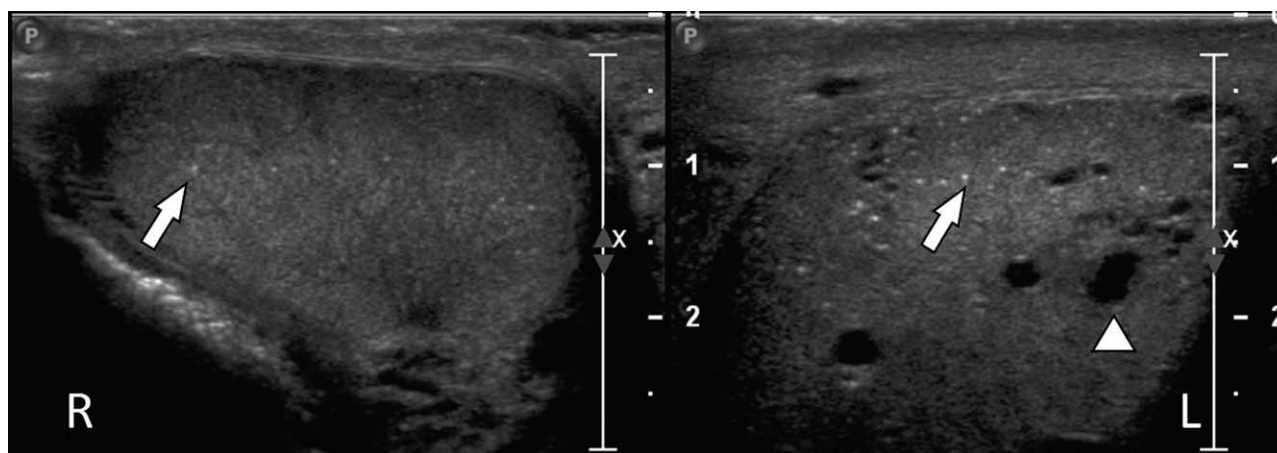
Longitudinal grayscale sonograms of the bilateral testes show nonshadowing punctate echoes consistent with microlithiasis (arrows) and anechoic structures within the left testicular parenchyma (arrowhead) representative of an intratesticular varicocele. L, left; R, right.
